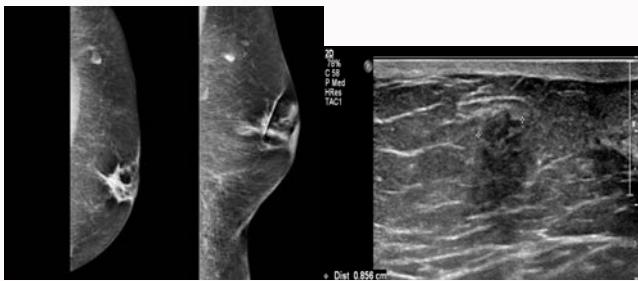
Diagnostic mammographic views of the patient's left breast: far left: CC view, center: MLO view, right: ultrasound.
